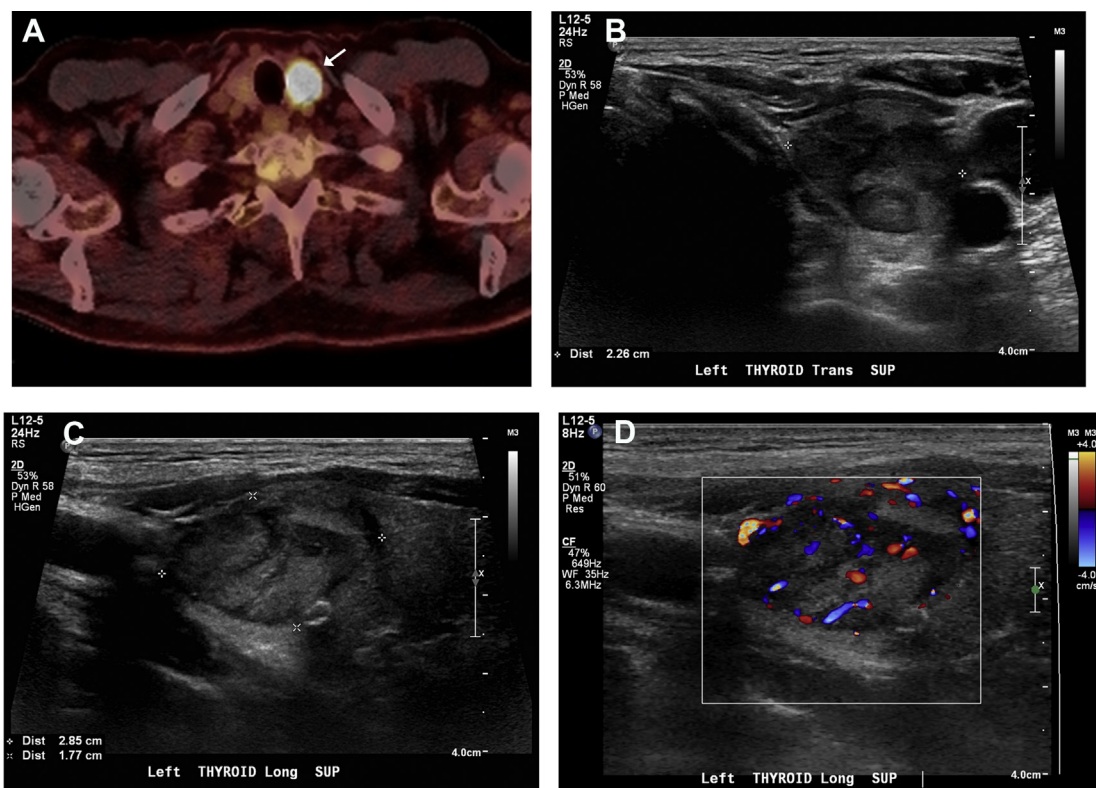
Staging PET-CT (A) for lung cancer shows a hypermetabolic thyroid nodule (arrow). Grayscale US (B, C) shows a 2.9-cm solid isoechoic-to-hypoechoic nodule (calipers) with a smooth regular margin, wider-than-tall shape, and absence of echogenic foci. Doppler US (D) demonstrates vascular flow within the nodule. FNA results were suspicious for a follicular neoplasm.
